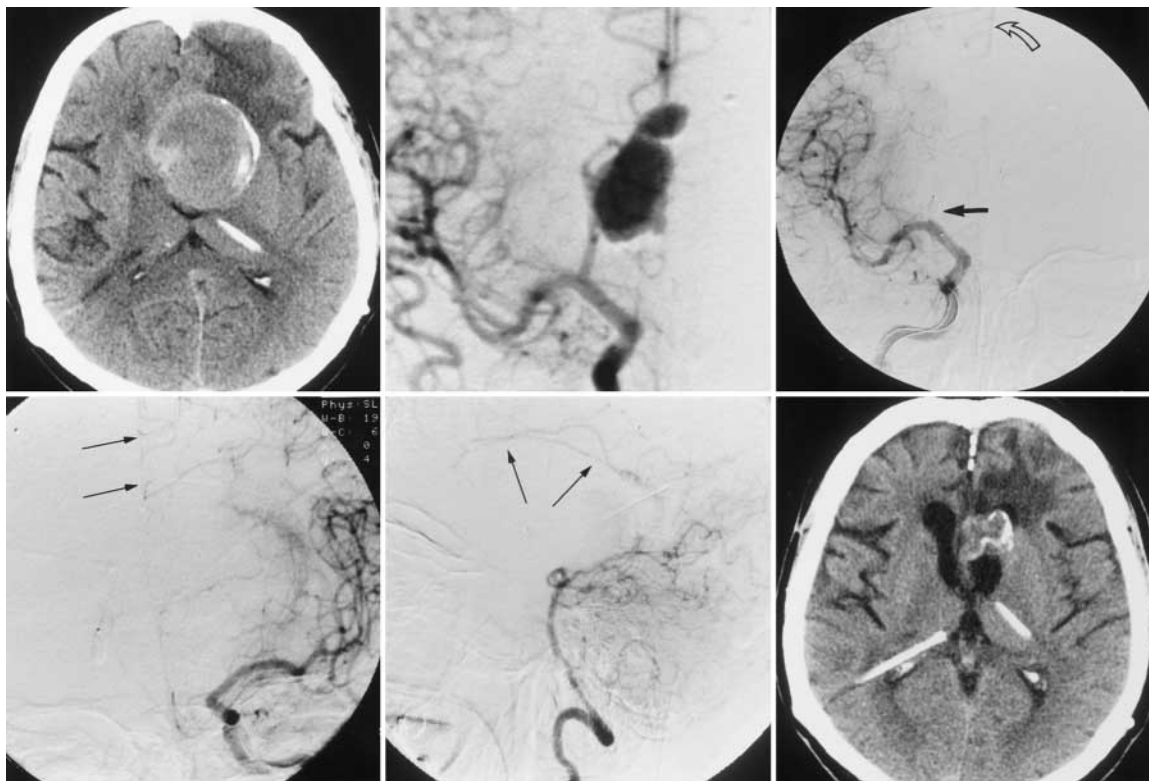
Case 17. *Upper Left*: Nonenhanced CT scan revealing a large mass near the interhemispheric fissure with rim calcification and overlying left frontal lobe hypodensity. *Upper Center*: Right common carotid artery angiogram (anterior projection) demonstrating that the right A₁ segment is bowed vertically. Beyond the aneurysm, the A₂ segments of both hemispheres are filled from the dominant right ACA. *Upper Right*: Right ICA angiogram (anteroposterior view) confirming that the right A₁ segment has been occluded by a detachable latex balloon (*straight arrow*). Leptomeningeal collateral flow is seen extending from the right MCA territory to the right ACA territory (*curved arrow*). *Lower Left*: Left ICA angiogram (anteroposterior view) obtained after detachment of the balloon. The absent left A₁ is noted. An exuberant collateral vessel is seen extending from the MCA to the left ACA (*arrows*). *Lower Center*: Left vertebral artery angiogram (lateral projection). Leptomeningeal collateral vessel passes from the posterior cerebral artery branches to the middle and anterior segments of the pericallosal arteries (*arrows*). *Lower Right*: Follow-up nonenhanced CT scan obtained 27 months after treatment. Note the marked reduction in the size of the mass.
